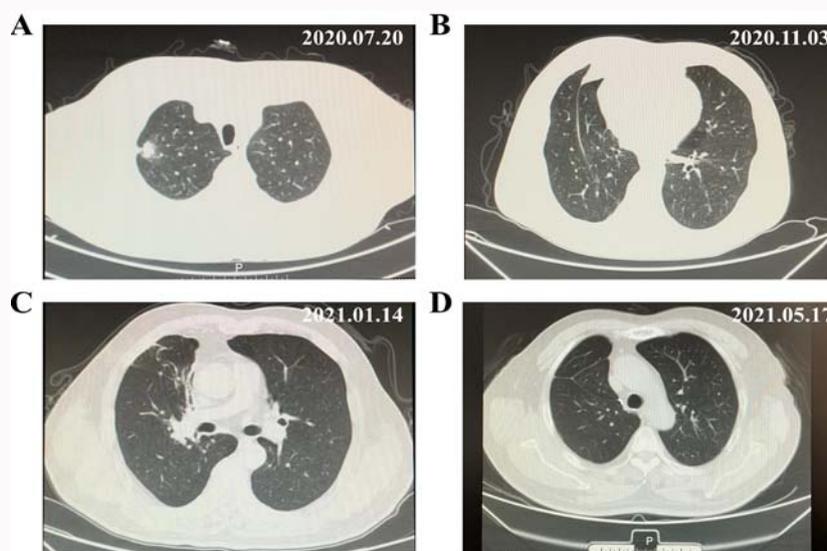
The chest computed tomography (CT) scan. (A) Before surgery. (B) After 3 months of postoperative. (C) After 4 months of chemotherapy. (D) After 10 months of postoperative.
